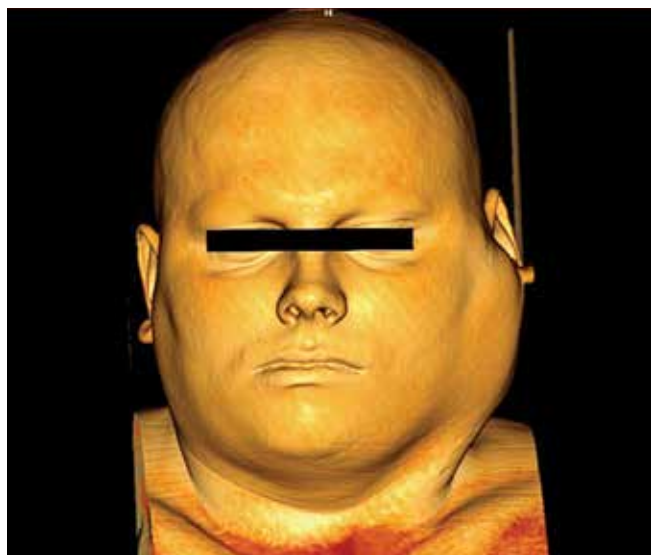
Computed tomography. 3D reconstruction of the appearance of patient S., 27 years. Marked swelling on the left lateral surface of the neck
